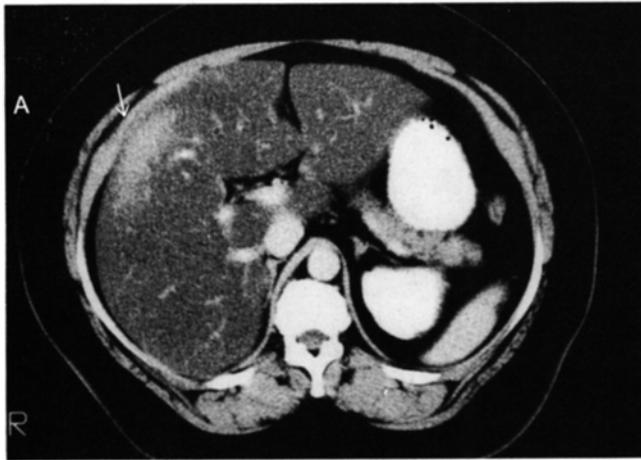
(A and B) CT images showing questionable areas as actual functioning liver tissue (arrows).
